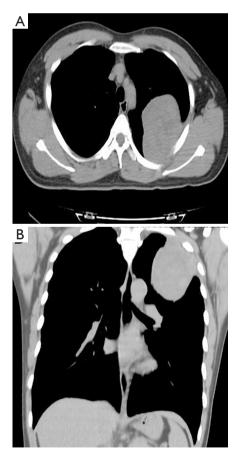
Chest CT scan demonstrated an $8 \text{ cm} \times 7 \text{ cm}$ mass with uneven density in the upper of left chest cavity. CT, computed tomography.
